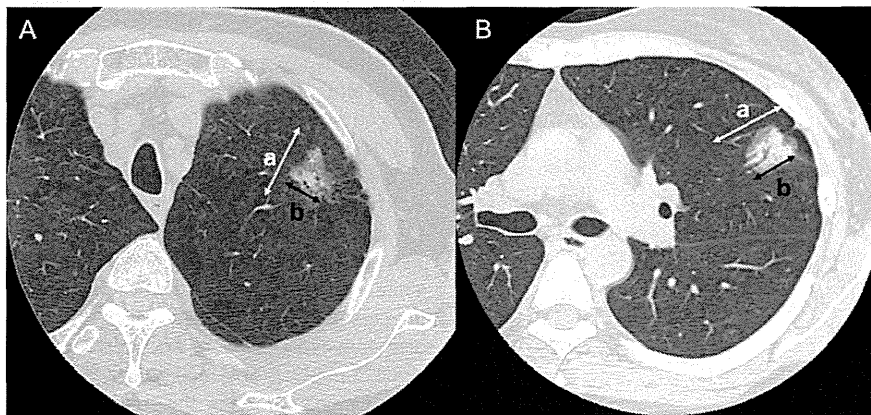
Findings of peripheral lung cancer on thin-section CT (A), (B); a: maximum tumour dimension, b: maximum dimension of consolidation defined as the size of area with increasing density without identifying its structure.
